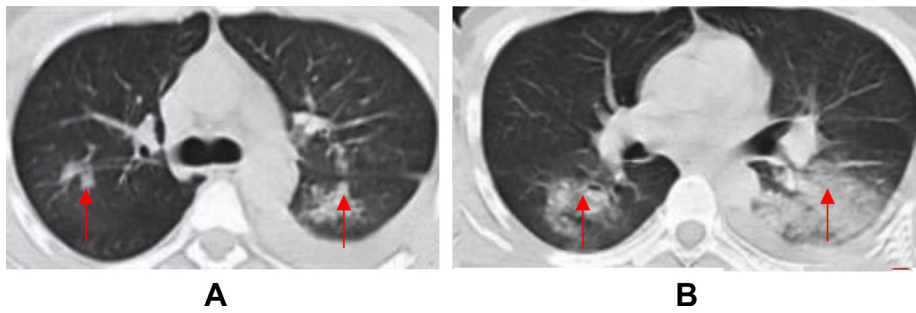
Male patient, 23 years old, fever for 4 day, no relevant contact history; CT examination; multifocal GGO in both lungs with patchy consolidation, present a multisegmental pulmonary distribution trend; pleural effusion (see the red arrows).
